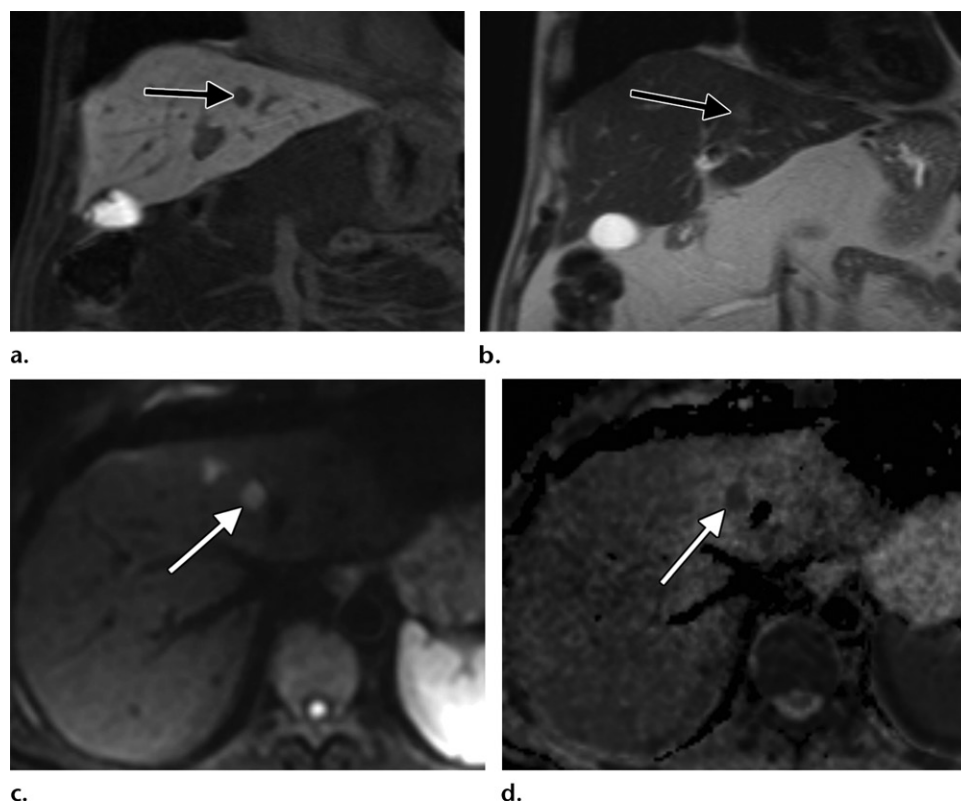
Colorectal cancer metastatic to the liver in a 51-year-old man. (a, b) Coronal T1-weighted hepatobiliary phase MR image obtained at 20 minutes after gadoxetic acid administration (a) and coronal SSFSE T2-weighted MR image (b) show a 1.4-cm metastatic lesion (arrow) in the left liver lobe. (c, d) Axial diffusion-weighted MR image ($b = 800 \text{ sec/mm}^2$) (c) and apparent diffusion coefficient map (d) show the restricted diffusion within the lesion (arrow).
